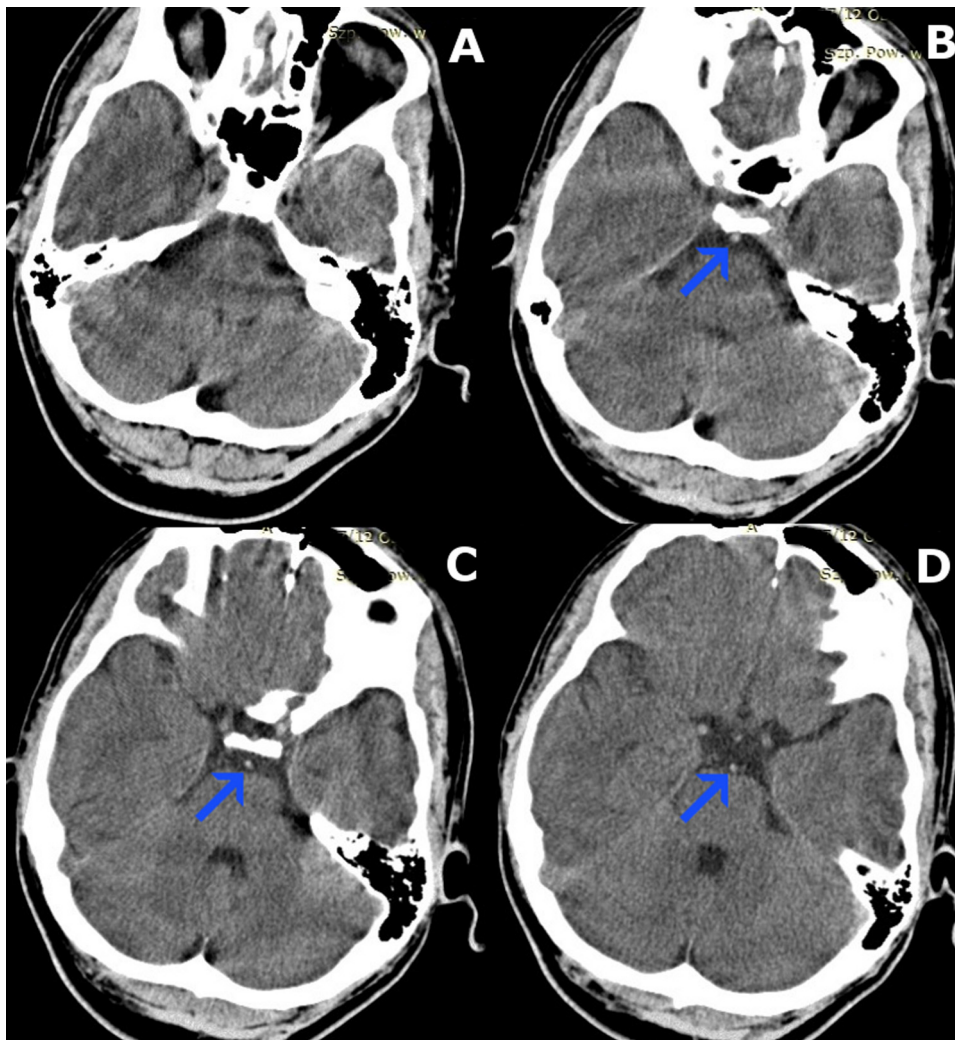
Computed tomography angiography (CTA). (B, C, D) Immediately after the onset of symptoms in municipal hospital, showing relative hyperdense basilar artery as compared to the middle cerebral arteries signifying acute thrombosis (arrowhead).
